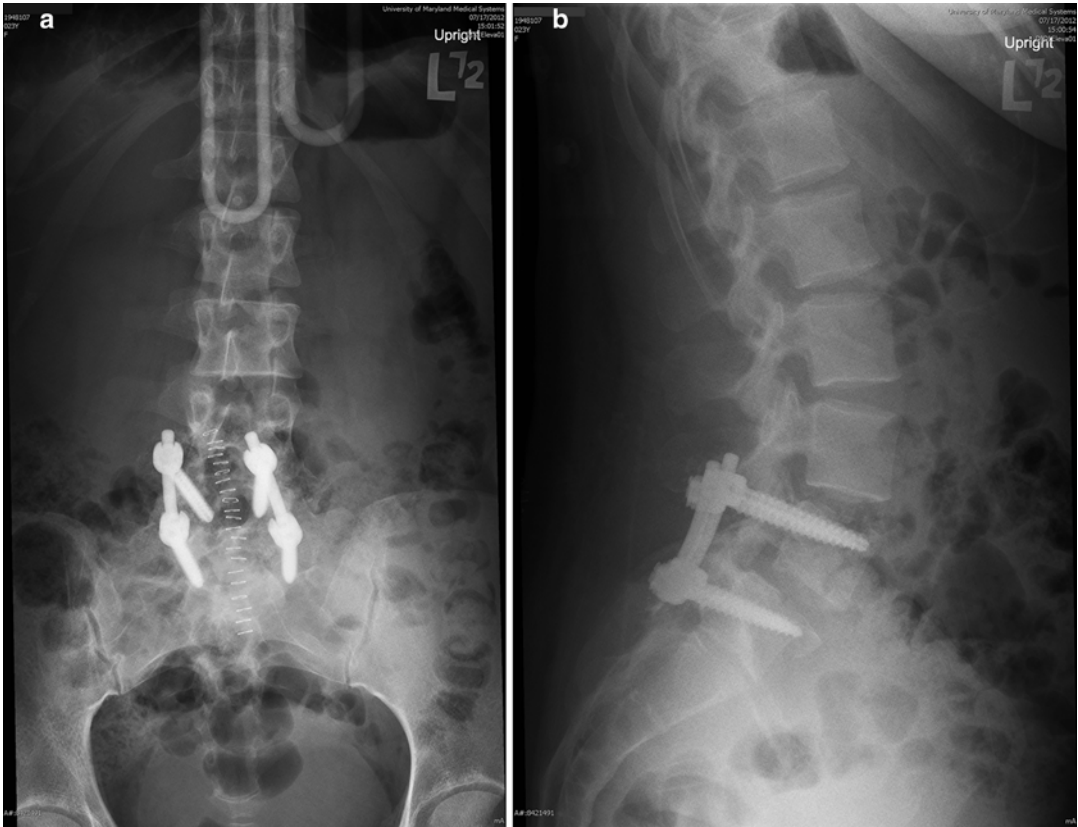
Postoperative upright radiographs of same patient shown in Fig. 20.3. (a) Anteroposterior view. (b) Lateral view
